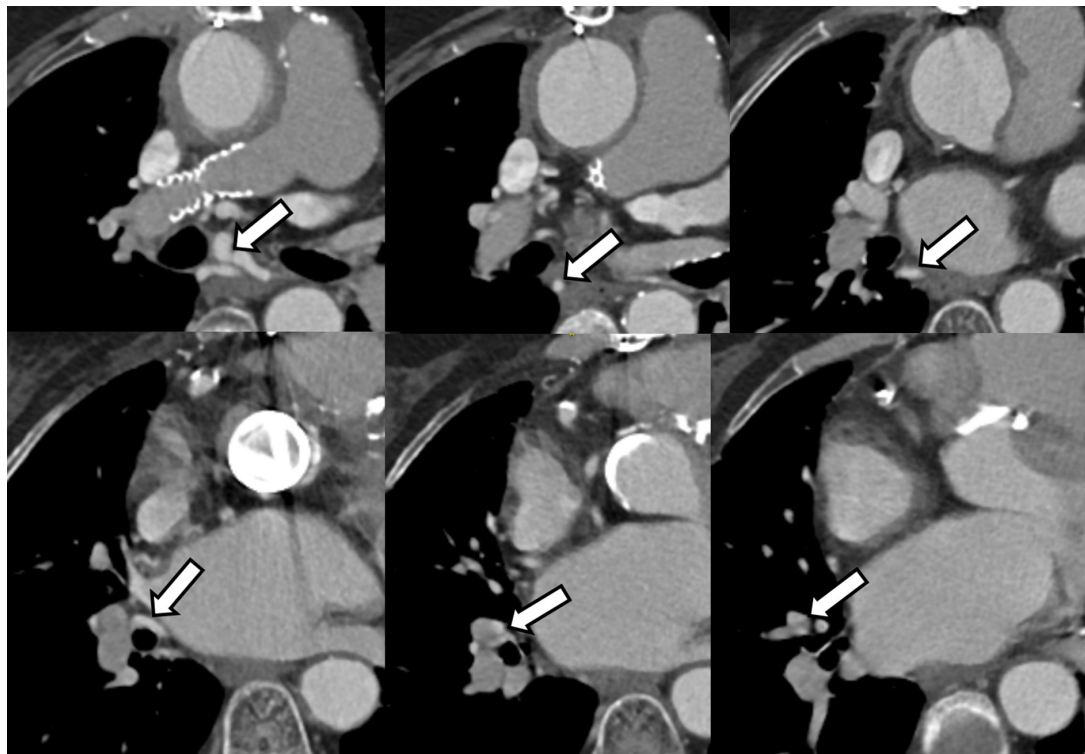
Axial CT images of the chest after administration of contrast (systemic arterial phase) demonstrate MAPCA (white arrows) extending into the right hilar region and connecting distally to the anterior segmental branch of the right lower lobe pulmonary artery. MAPCA, major aortopulmonary collateral artery.
